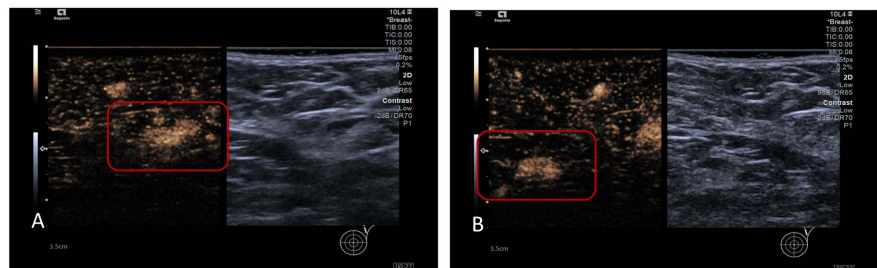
Transvenous ultrasonography. (A) shows inhomogeneous hyperenhancement (pathology with metastasis) and cortical filling defects; (B) homogeneous hyperenhancement (pathology without metastasis).
